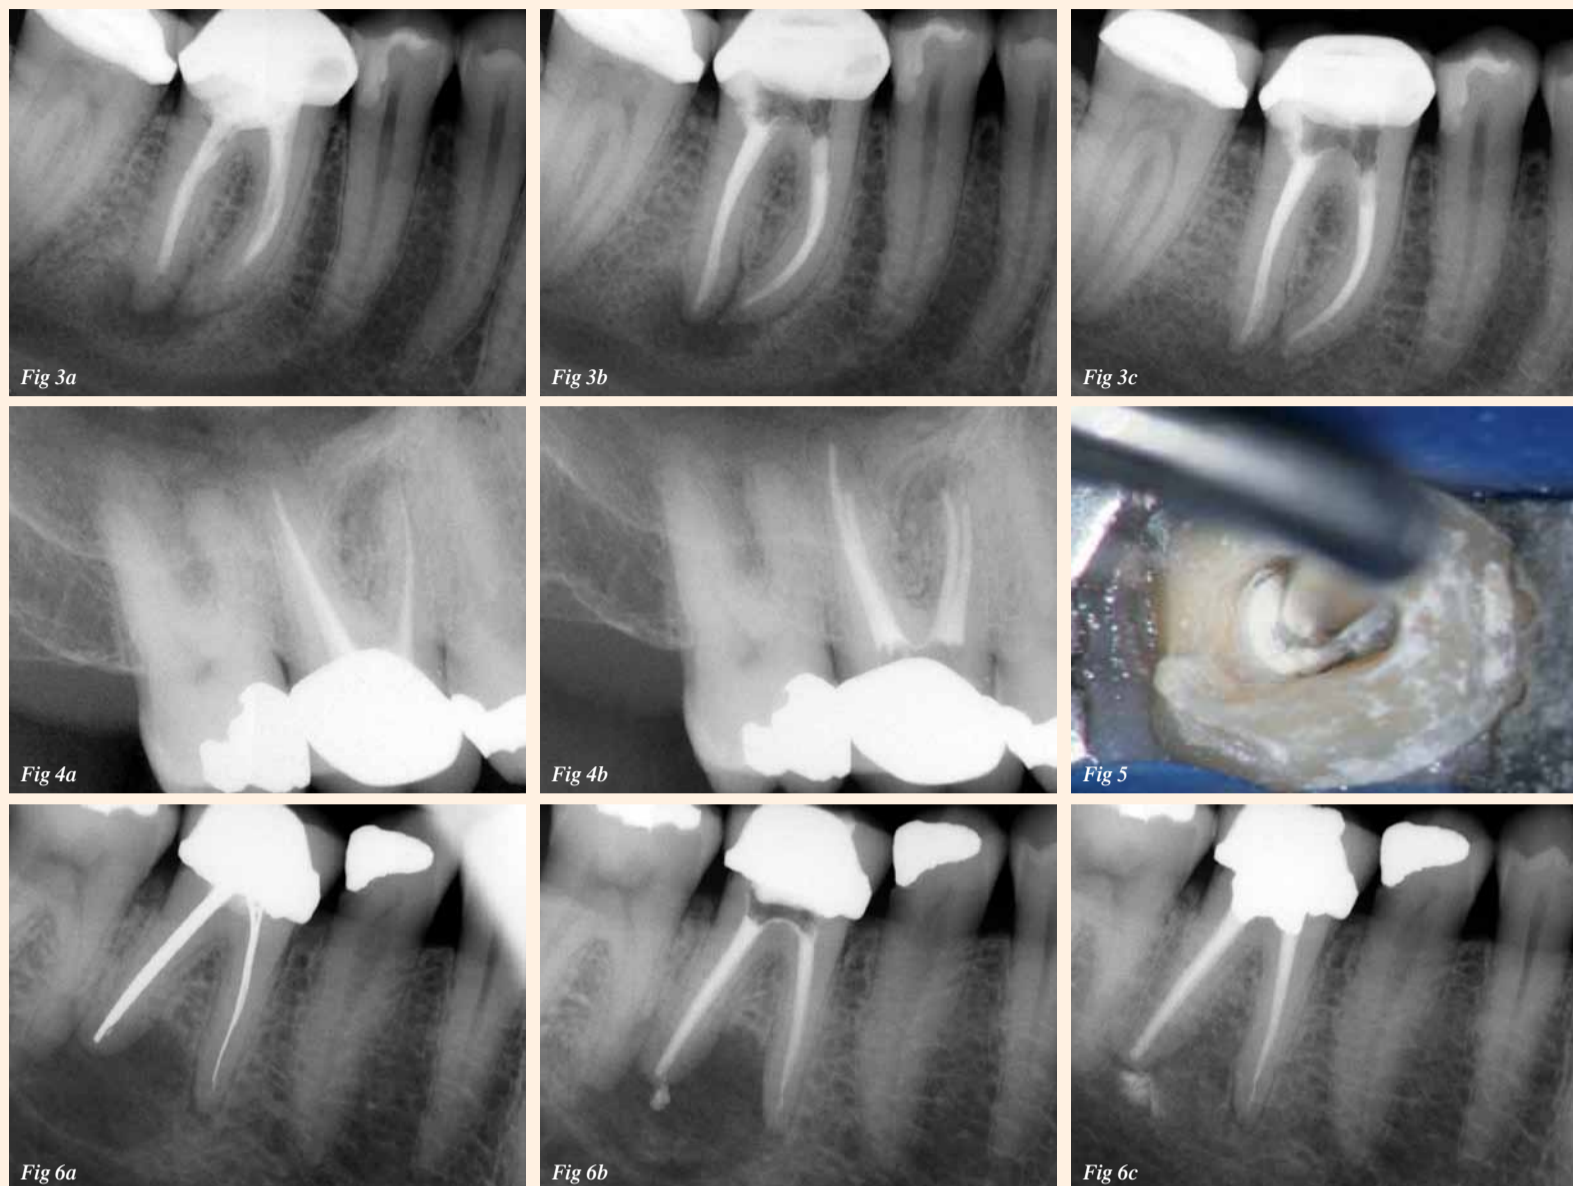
Tooth #30 with a radiolucent periapical lesion with evidence of incomplete cleansing, shaping and obturation.—Fig. 3b: Post-op radiograph.—Fig. 3c: Thirteen-month follow-up radiograph. (Courtesy of Dr Brett E Gilbert)—Fig. 4a: Tooth #3 with a radiolucent periapical lesion on the mesiobuccal root apex.—Fig. 4b: Post-op radiograph showing treatment of the second mesio Buccal canal and appropriate lengths on retreatment of the distobuccal and palatal canals. (Courtesy of Dr Brett E Gilbert)—Fig. 5: Photograph displays excellent visibility and magnification of the pulp chamber with the use of an ultrasonic tip. (Courtesy of Dr Scott Bentkover, USA)—Fig. 6a: Tooth #3 with silver-point fillings in the mesial root and a large post in the distal root. A large radiolucent periapical lesion is evident on the distal root.—Fig. 6b: Post-op radiograph.—Fig. 6c: Thirteen-month follow-up radiograph. (Courtesy of Dr Brett E Gilbert)
